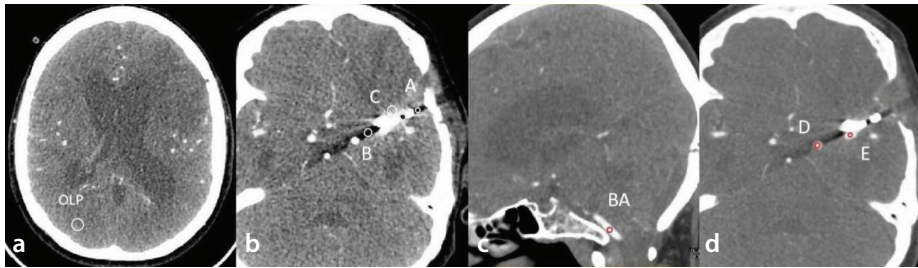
An example of manually designating regions of interest in conventional computed tomography angiography images at different slices or different window widths and levels. (a) The occipital lobe parenchyma is drawn in the right occipital lobe, avoiding vessels, malacic foci, and hemorrhage. (b) Draw A, B, and C in the areas with the worst artifacts in the metal clip's head, tail, and middle part, respectively. (c) BA is located in the basilar artery. (d) D and E are located in the vessels with the worst artifacts in the tail and middle part of the metal clip, respectively.
